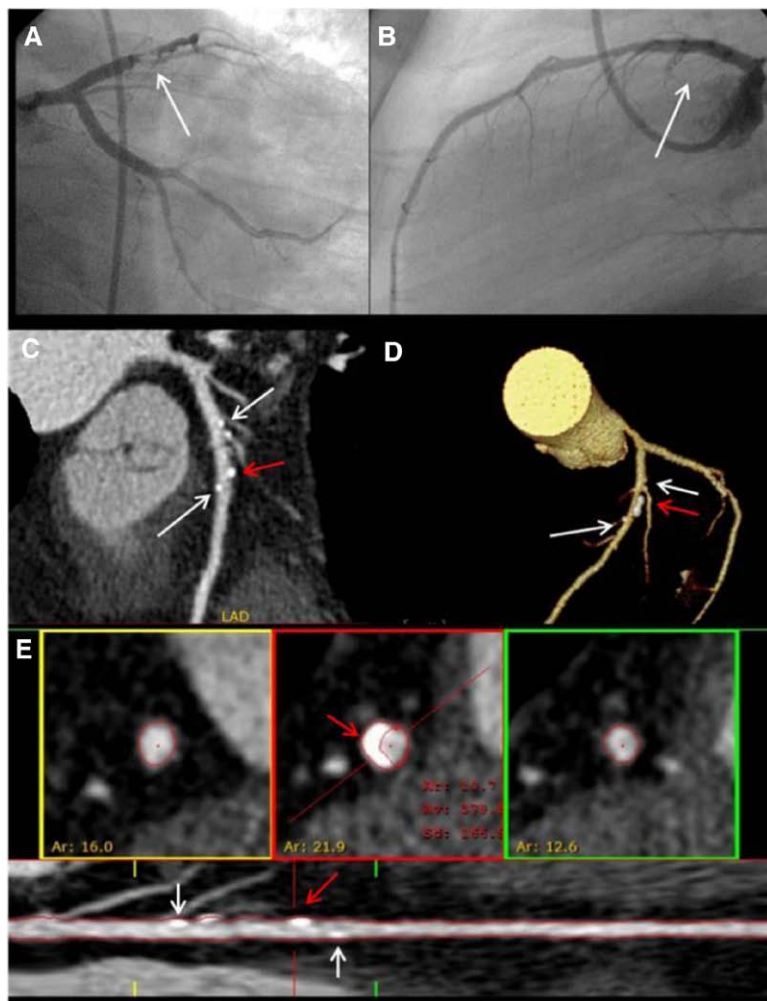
Fifty-two-year-old man referred for anterior ST-segment-elevation myocardial infarction (STEMI). A, 95% left anterior descending (LAD) stenosis with thrombi and thrombolysis in myocardial infarction (TIMI) 2 flow was predilated, and (B) bioresorbable vascular scaffold (BVS) 3.5/18 mm was implanted. At curved multiplanar reconstruction (MPR; C) and 3D volume rendering (D) reconstructions of LAD, proximal and distal markers of BVS are clearly identified (white arrows). Dense eccentric calcified plaque at distal part of scaffold (red arrow). Quantitative multislice CT (MSCT) analysis (E): yellow and green boxes show proximal reference lumen areas that were traced and measured. After analysis of scaffold area slice by slice of 0.5 mm thickness, cross-section of minimal lumen area was identified (red box) and vessel wall and lumen were traced (red color lines). Lumen area stenosis was 25.2% (reference lumen area was 14.3 mm² minimal in-scaffold lumen area 10.7 mm²). Notice positive vessel wall remodeling because of large calcified plaque behind scaffold at cross-sectional seen in red box.
